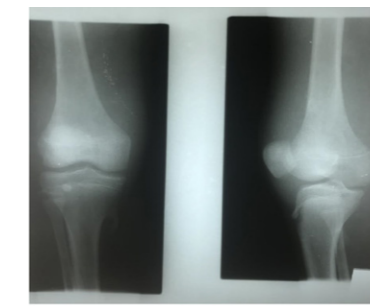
Knee x-ray: pre-arthrotomy knee x-ray. No signs of septic arthritis noted on x-ray
